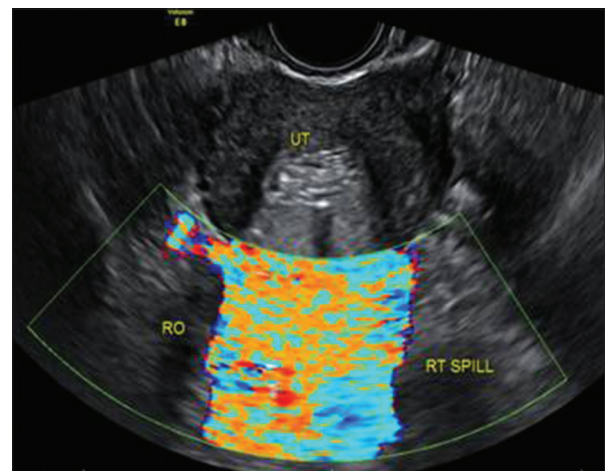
Patent tube filling the color box on Doppler
